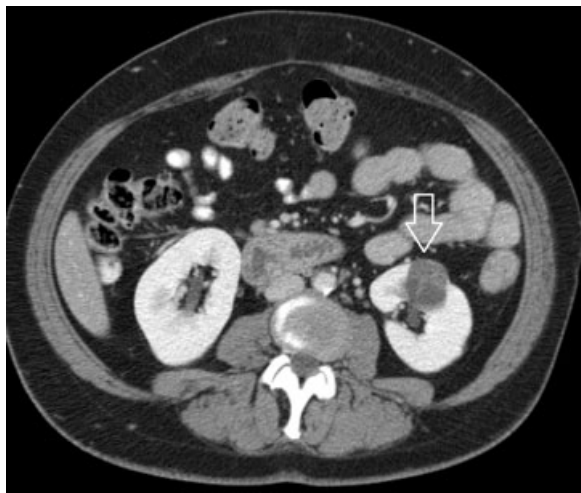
Axial contrast-enhanced computed tomography of a left clear cell renal cell carcinoma (arrow) measuring 3.7 cm in maximal dimension indicating a T stage of T1a.
